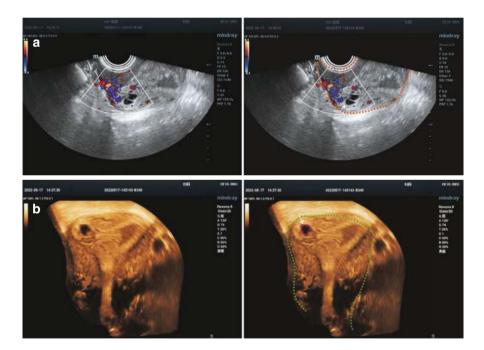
(a) Angular pregnancy: The gestational sac is located at the uterotubal junction and encircled by endometrium; CDFI shows blood flow signals around the gestational sac. The uterus is outlined in orange; the white arrow indicates the gestational sac. (b) 3D ultrasound showing a gestational sac at the uterotubal junction. The uterus is outlined in green; the gestational sac is circled in pink; the white arrow indicates the uterotubal junction
